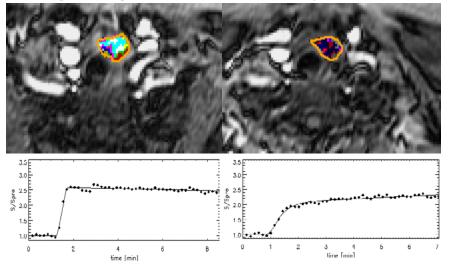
DCE-MRI parametric maps and signal intensity curves within the tumor ROI for the baseline (Left column) and the follow up after treatment (Right column).
